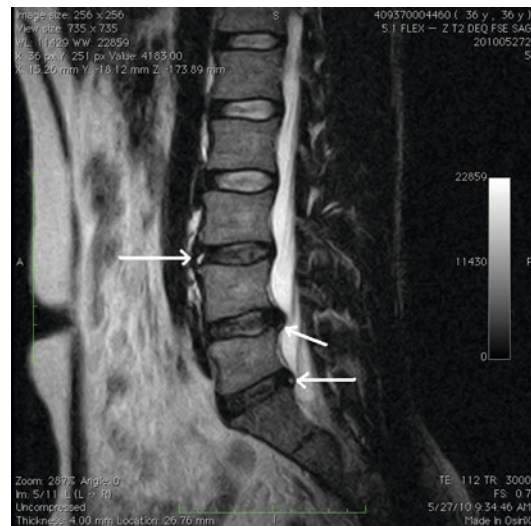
A T2-weighted sagittal MRI scan of the lumbar spine demonstrates three high-intensity zones (arrows) visible at L3–4 (anterior) and L4–5 and L5–S1 (posterior)
